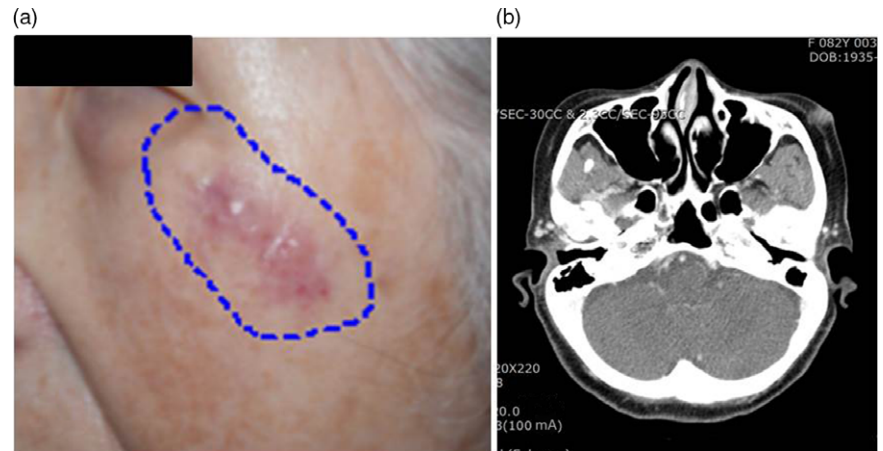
(a) Appearance of Merkel cell carcinoma on left cheek of patient. (b) Computed tomography at diagnosis.
